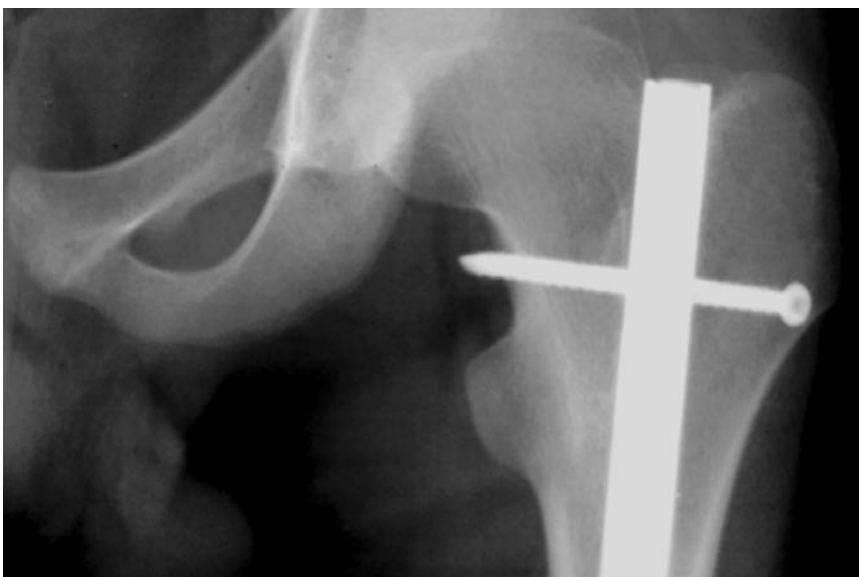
Postoperative anteroposterior left hip x-ray taken at 16 years 0 month shows intramedullary nail in center of medullary canal.
